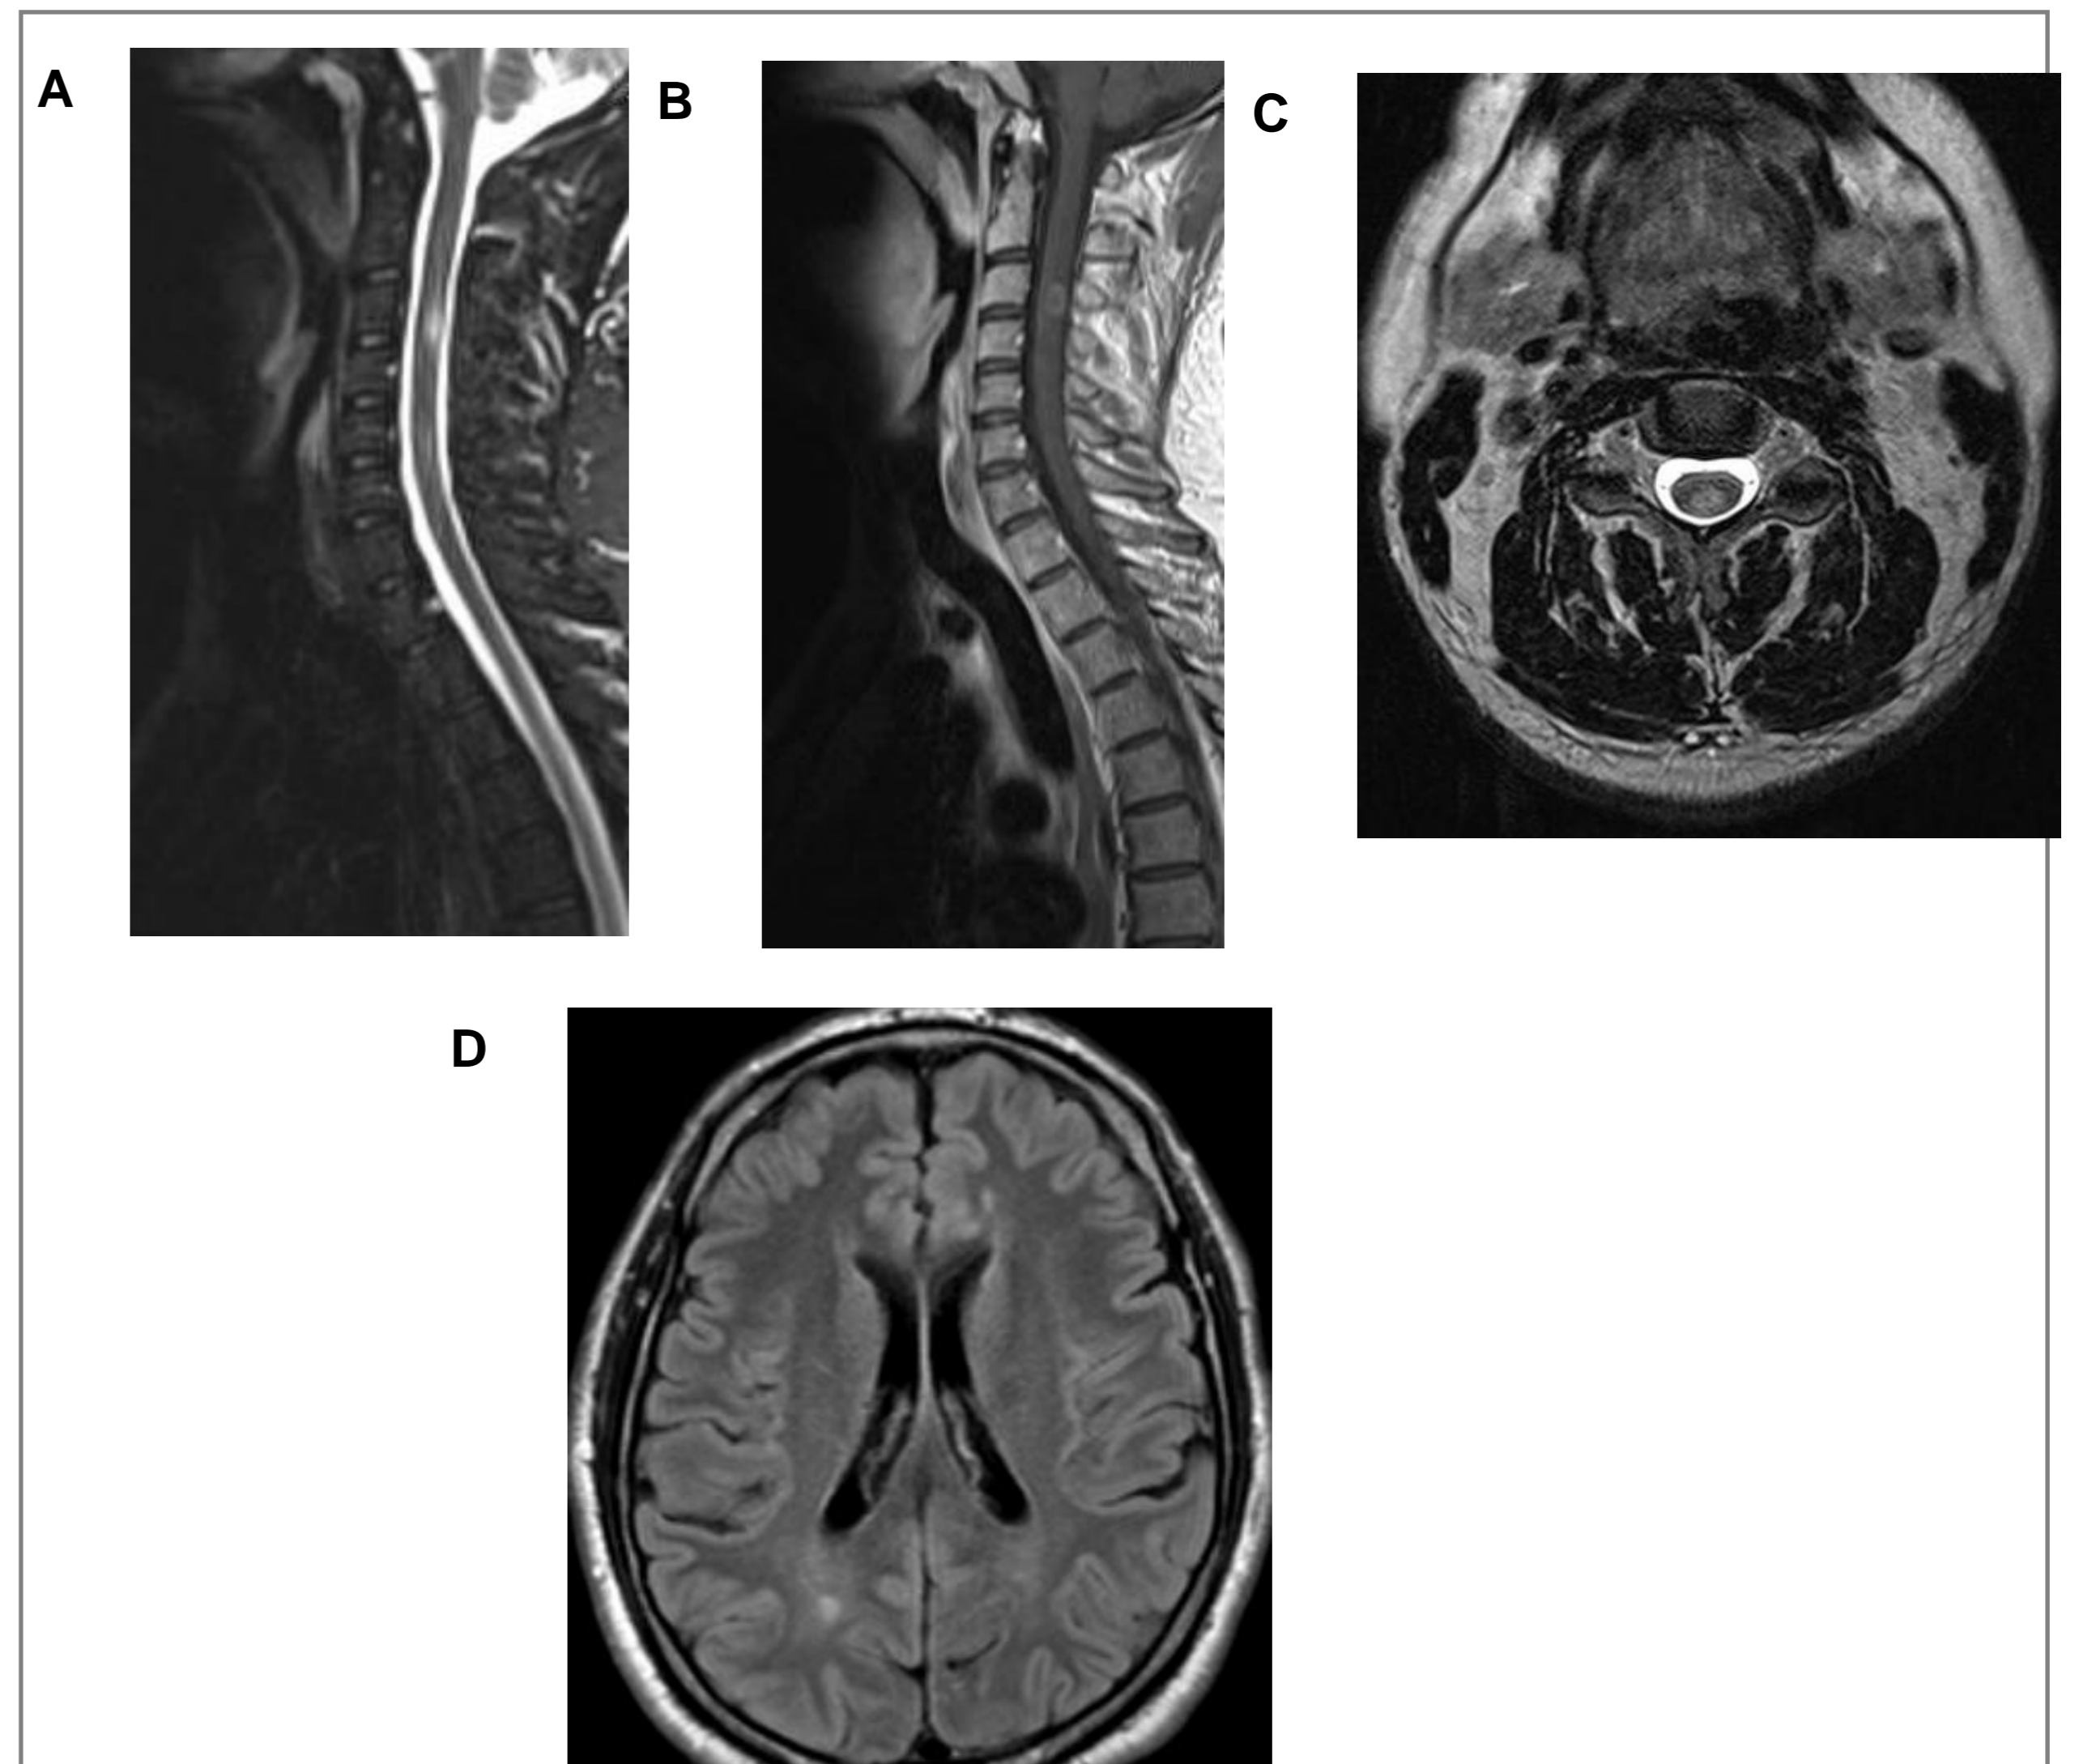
MRI at presentation. Panel A: sagittal, T2 weighted spinal MRI. Panel B: sagittal, T1 weighted, Gd + spinal MRI. Panel C: axial, T2 weighted, spinal MRI. Panel D: axial FLAIR brain MRI
